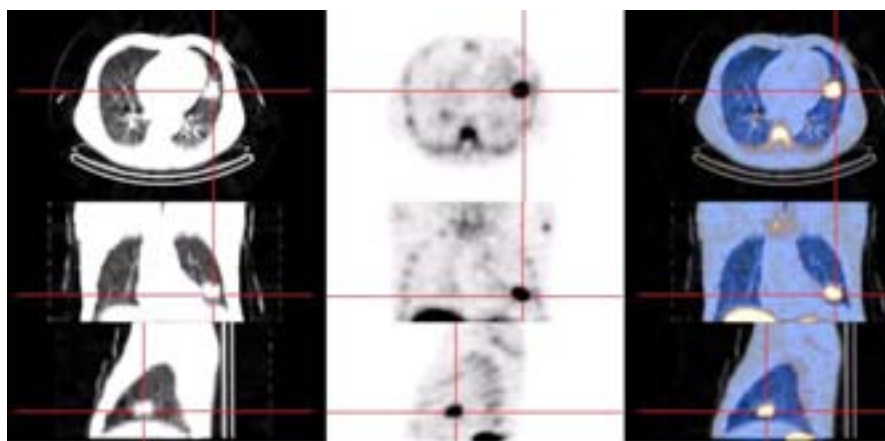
Transaxial, coronal, and sagittal tomograms of SPECT/CT imaging obtained after injection of ^{99m}Tc -depreotide in a patient with a solitary pulmonary mass occasionally discovered on chest X-ray. Intense tracer uptake indicates malignancy, while the fused SPECT/CT images suggest that, while there is no extension of the tumour to infiltrate the chest wall, there is possible involvement of the pericardium.
